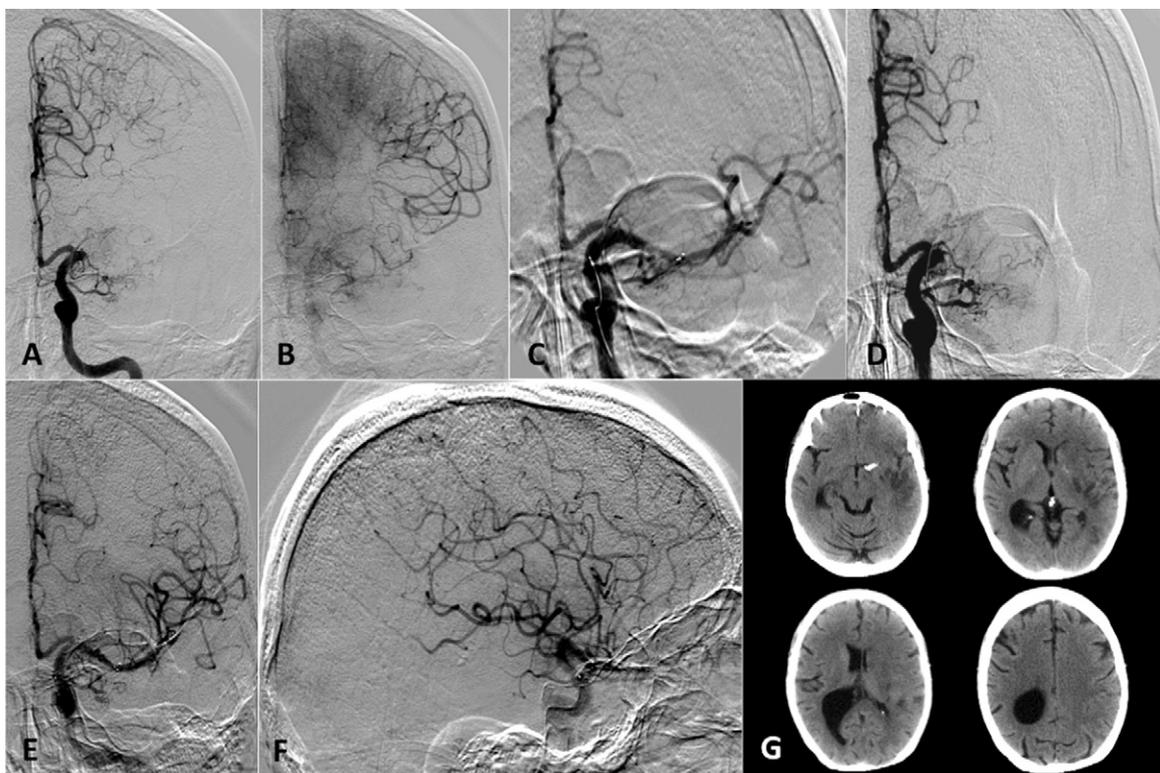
(A) Patient presenting with occlusion of M1 proximal segment of the MCA. (B). Good Leptomeningeal collateral circulation through the anterior cerebral artery. (C). Deployment of the Solitaire AB (4×30 mm); bypass phenomenon through the stent is evident. (D). Recanalization failure after 4 thrombectomy attempts. (E, F). Restored flow after Solitaire AB deployment and subsequent detachment. (H). CT scan at 1 month shows infarction of the left basal ganglia and of the ipsilateral anterior temporal lobe.
